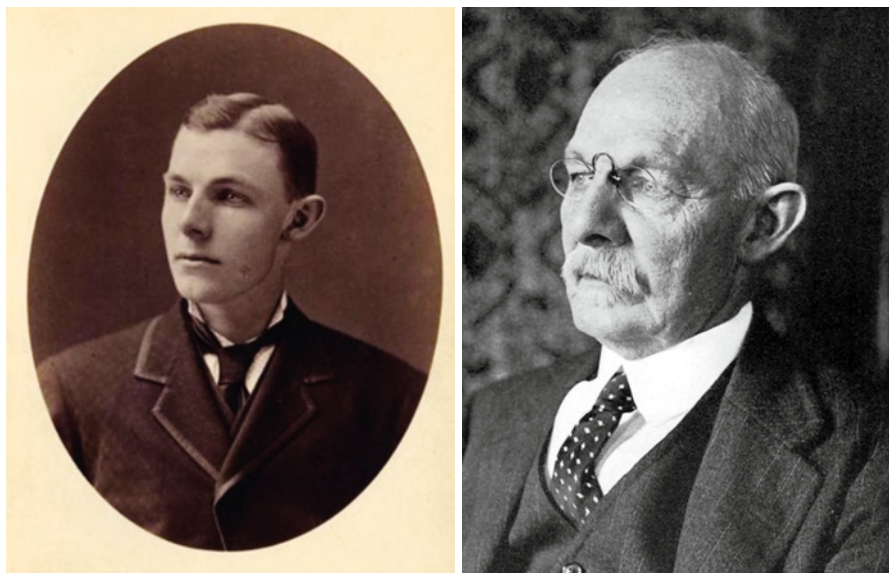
Dr. William Stewart Halsted (1852–1922). Portrait of William Stewart Halsted, Yale College class of 1874 (Photograph courtesy of the Yale University Manuscripts & Archives Digital Images Database, Yale University, New Haven, CT)
